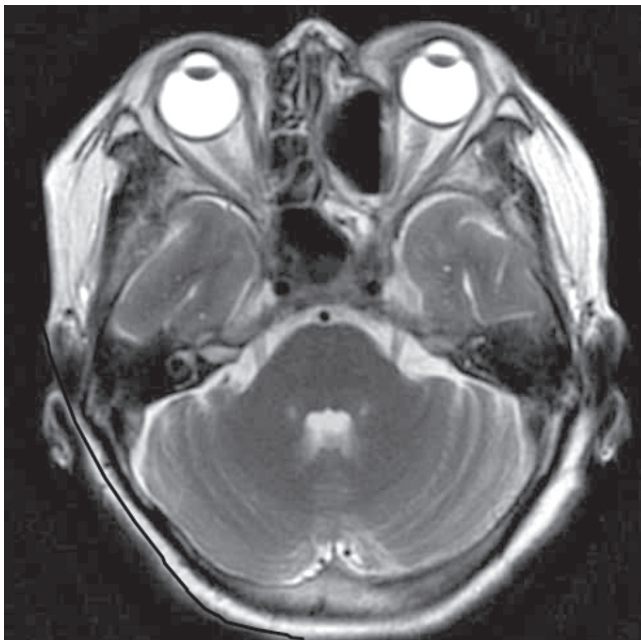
Postoperative MRI revealed that mucocoele had been excised
